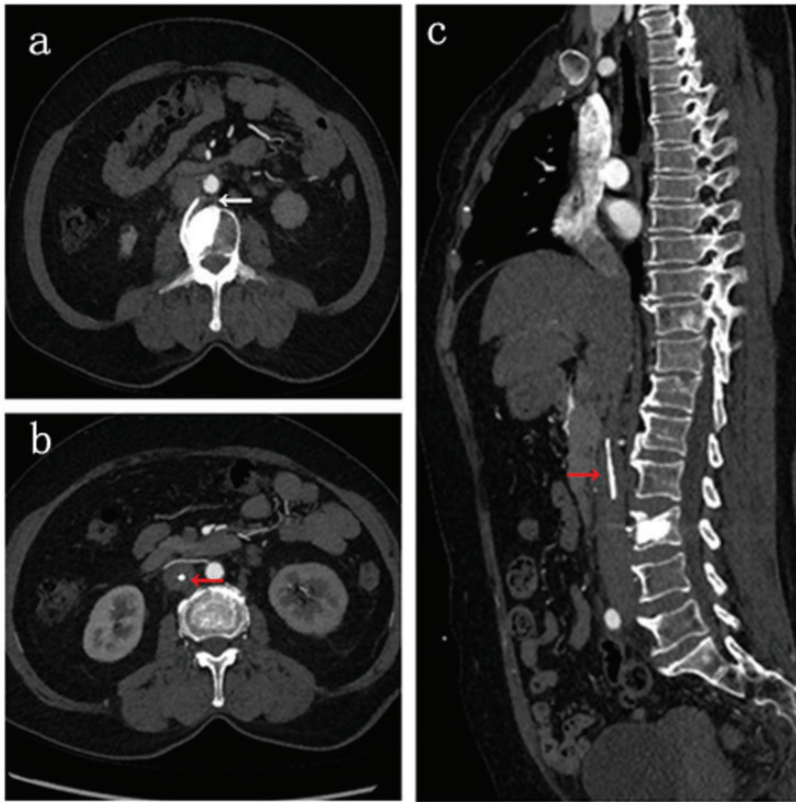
Computed tomography shows that cement leakage started from L3 (a) (white arrow), migrated to L1 (b) (red arrow), and then became suspended in the inferior vena cava (c) (red arrow).
